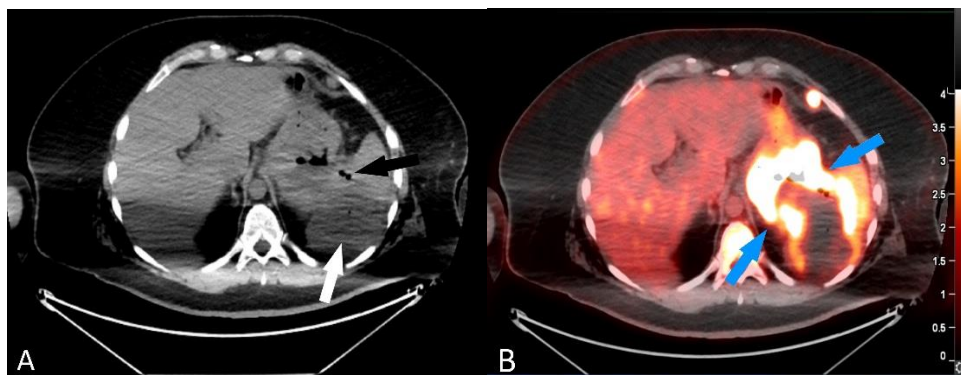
Axial CT (A) and fused PET/CT images at the same level (B). Coronal fused PET/CT image (C) and PET MIP (Maximum Intensity Projection) (D) demonstrate an intensely FDG mass (blue arrows) involving stomach and spleen with areas of central splenic necrosis (white arrow) and small locules of air (black arrow). Coronal PET/CT and PET MIP images demonstrate FDG avid multistation adenopathy above and below the diaphragm and diffuse intense bone marrow uptake.
